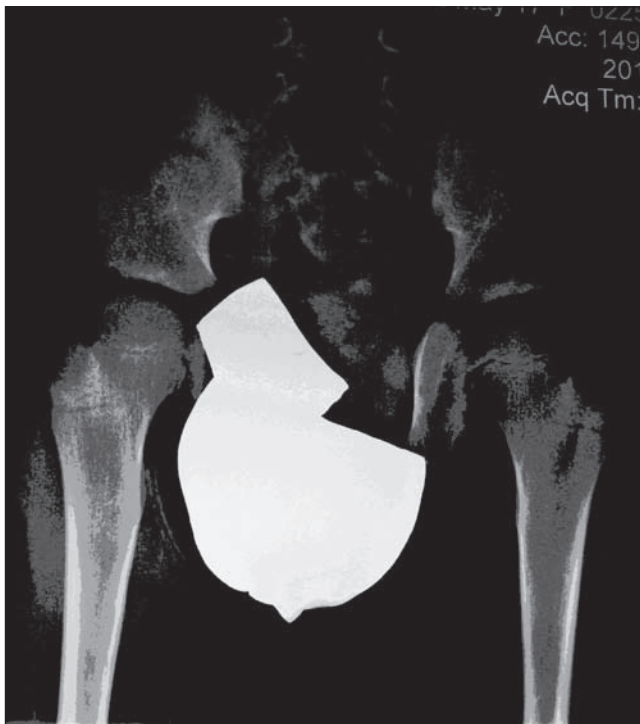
Pelvic girdle X-ray which shows the acetabular hypoplasia.
